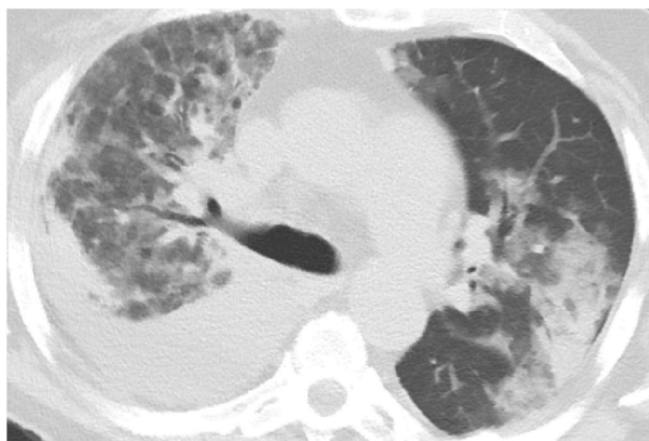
A chest HRCT scan showing new consolidations on the left lung as well as new diffuse ground glass opacities and increased right pleural effusion.
